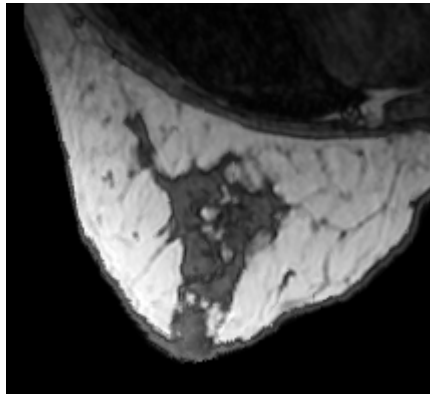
Original MRI Image.
